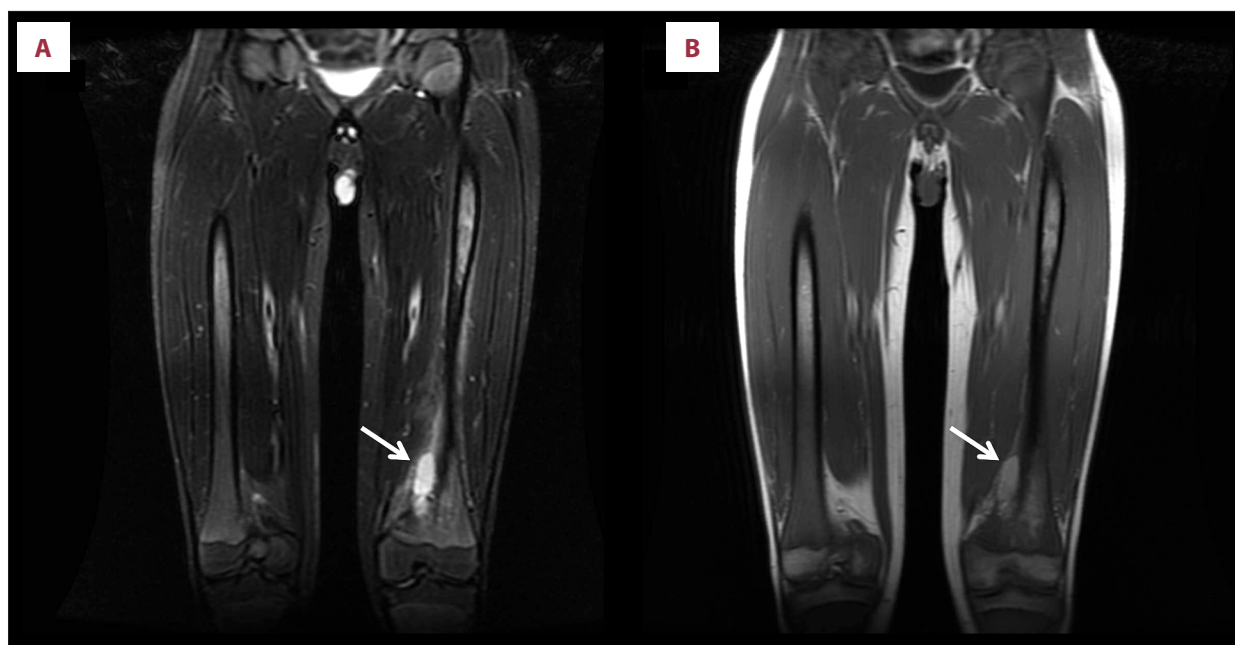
Magnetic resonance imaging findings during acute skeletal presentation. Coronal magnetic resonance imaging of the lower extremities. (A) Short tau inversion recovery sequence demonstrates a heterogeneous area of increased signal intensity within the distal metaphysis and diaphysis of the left femur, suggestive of bone marrow edema or infiltration. (B) Corresponding T1-weighted image shows reduced signal intensity in the same region, indicating replacement of normal bone marrow. White arrows indicate the abnormal marrow lesion within the distal femur. No cortical destruction or periosteal reaction is observed. Overall, the imaging findings are consistent with an acute bone crisis in Gaucher disease.
